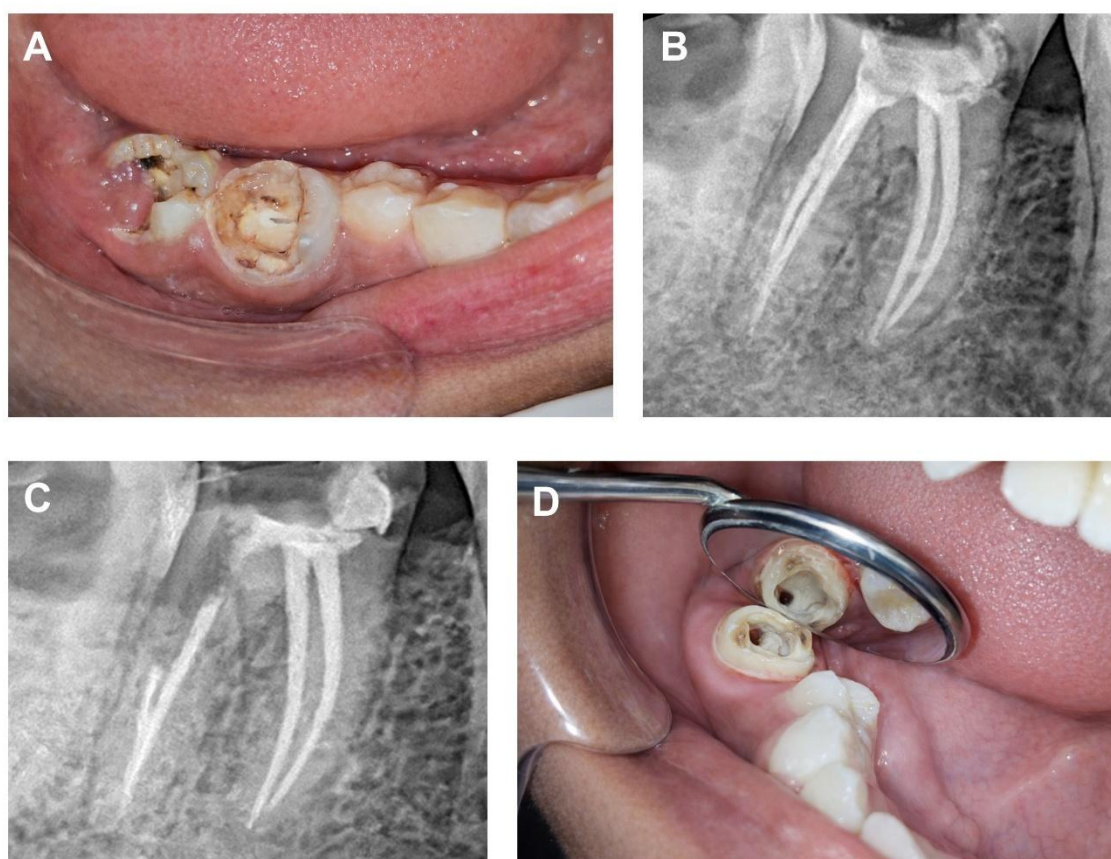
Clinical and radiographic sequence of diagnosis, endodontic treatment, and post space preparation. (A) Preoperative clinical photograph showing extensive coronal destruction of the mandibular right first molar (tooth 46). (B) Post-obturation periapical radiograph following nonsurgical root canal treatment. (C) Periapical radiograph showing post space preparation with approximately 4 mm of apical gutta-percha preserved. (D) Occlusal view of the tooth following post space preparation, demonstrating the remaining coronal tooth structure prior to fabrication of the definitive Richmond crown.
